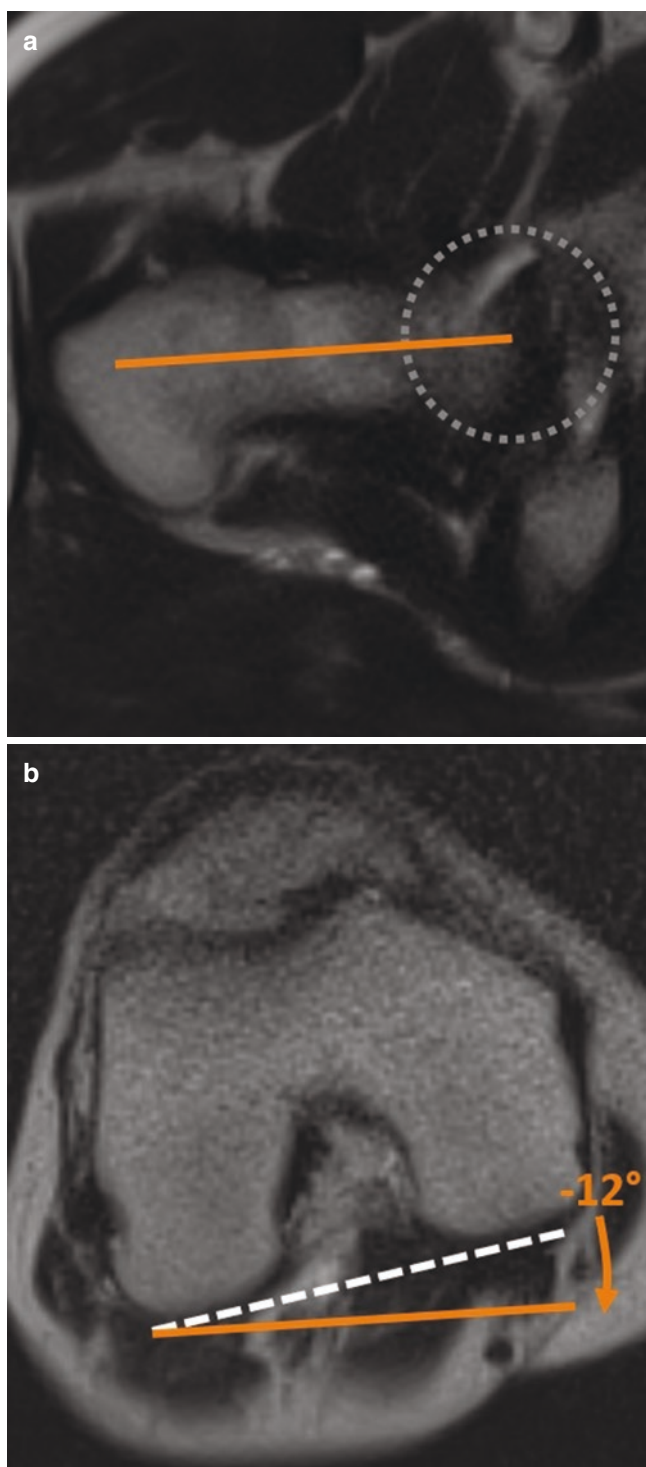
Femoral retrotorsion in a 33-year-old man with hip pain. Axial T2 MR images over the proximal (a) and distal (b) femur show that the femoral neck axis (orange line in a) is oriented in 12° retroversion compared to the tangent at the femoral condyles (dashed white line in b). No cam or pincer deformities were seen in this patient
